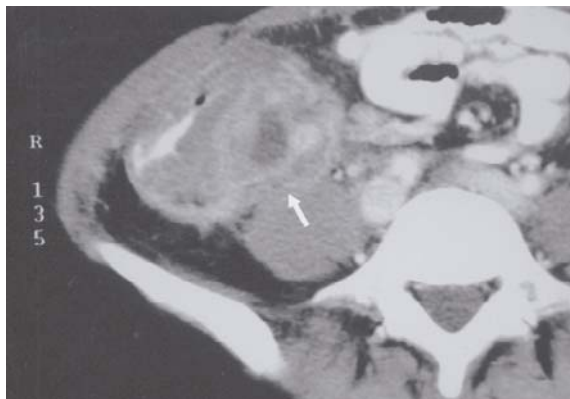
Enhanced axial CT image shows an appendiceal abscess (arrow).
